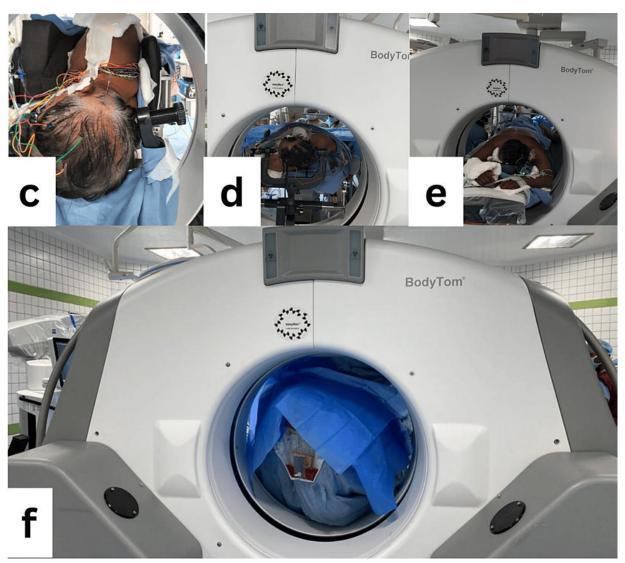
Demonstrating the Application of Intraoperative CT (iCT) in Neurosurgical Settings
